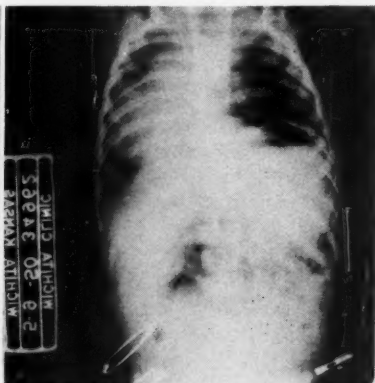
X-ray showing expanded left lung after surgery and heart in right chest.
